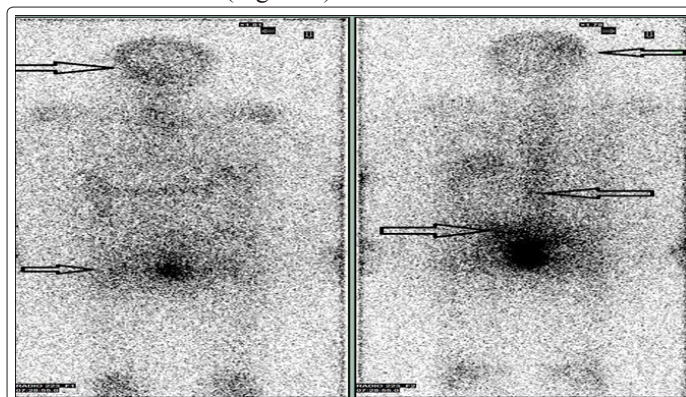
The evaluation of the deposit areas of radium 223 showed a perfect overlap with the regions of osteolysis previously detected by scintigraphy
